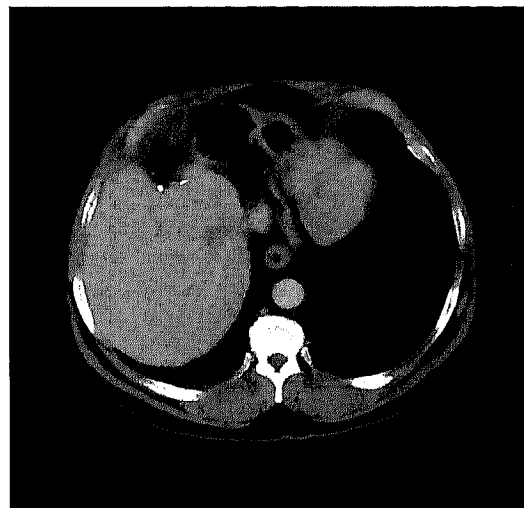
Computed tomogram of the electrolytically treated lesion in the same patient 3 months after electrolysis, showing fibrosis and shrinkage of the treated area
